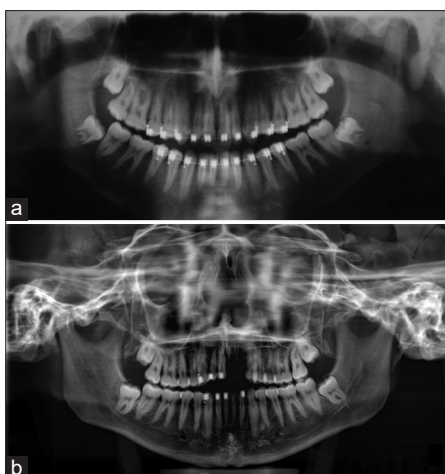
Comparison of antemortem (a) and postmortem (b) panoramic radiographs
